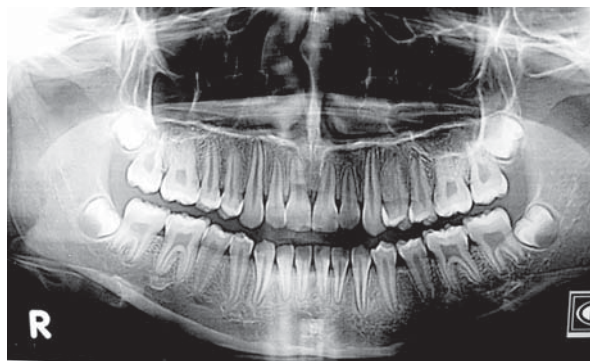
Orthopantomographic view of the female garment worker showing the developing third molar.
